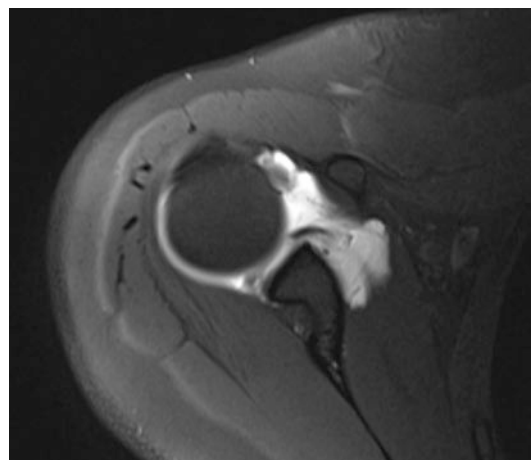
Oblique axial MR image demonstrating tear extension into the posterosuperior labrum
